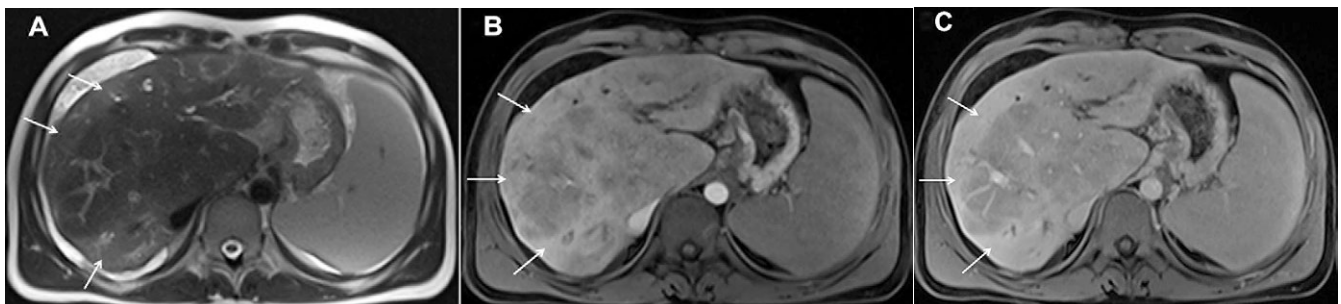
Primary sclerosing cholangitis in a 44-year old man. Axial T2-weighted image shows increased signal in peripheral, atrophic regions in the right liver lobe (arrows), corresponding to areas of parenchymal inflammation, and increased water content (A). Axial 3-dimensional gradient-echo (GRE) VIBE (volumetric interpolated breath-hold examination) image in the same patient obtained after i.v. administration of gadolinium chelates during arterial phase (B) and portal-venous phase (C) shows increased enhancement of peripheral areas of liver (arrows) representing intrahepatic perfusion changes.
